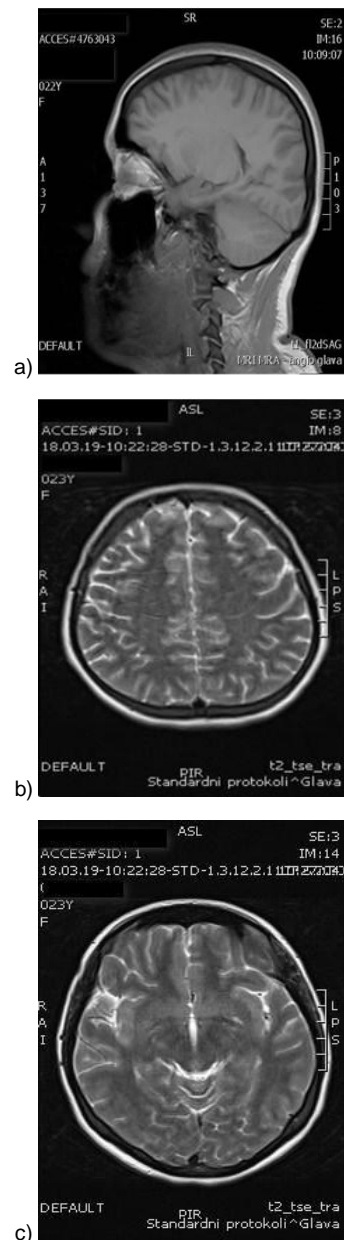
Control MRI of the cranium
